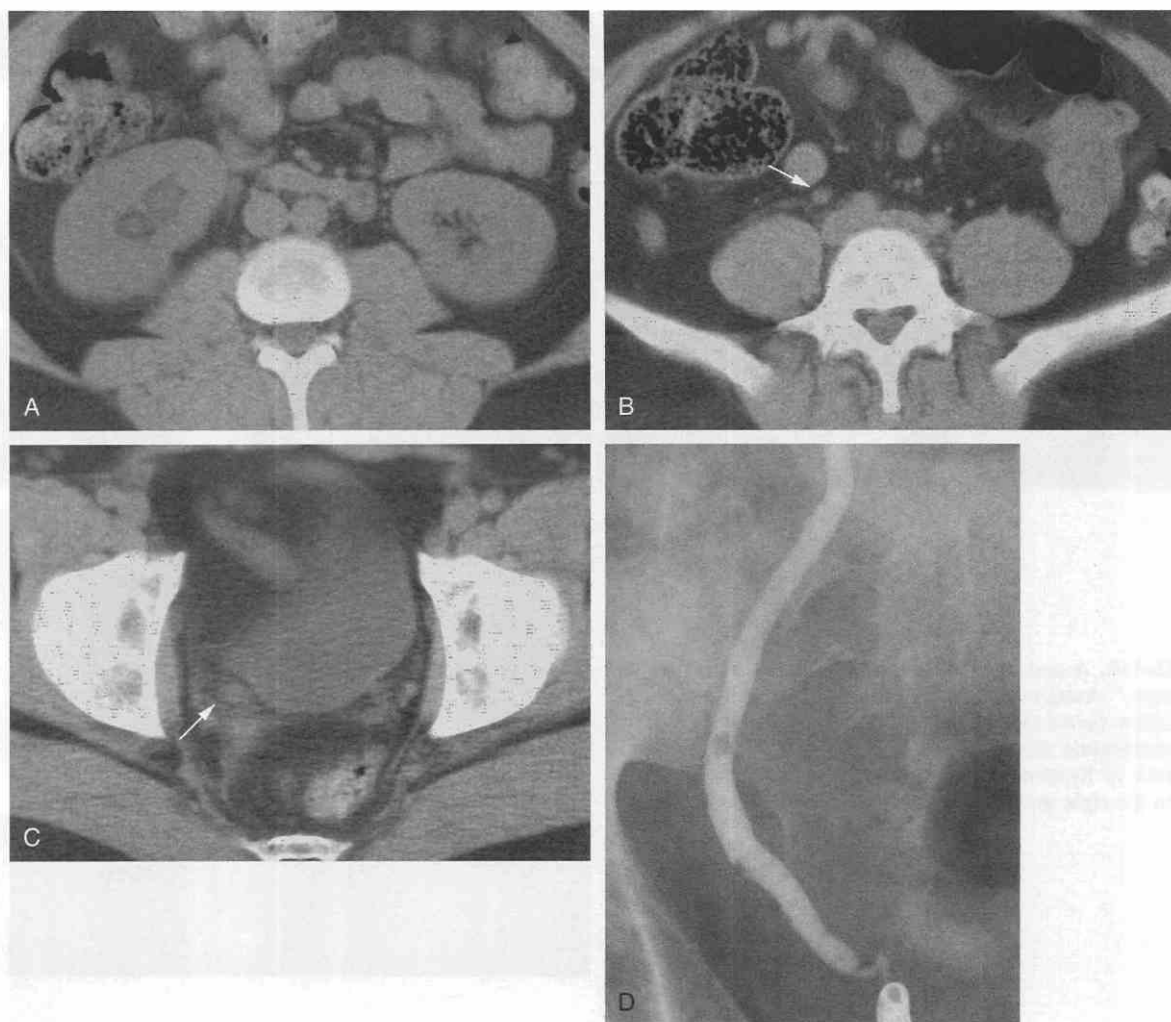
Protease inhibitor deposition in a 35-year-old man with human immunodeficiency virus disease who is undergoing indinavir therapy. *A*, Axial non-contrast CT scan reveals hydronephrosis and minimal perinephric stranding of the right kidney. *B*, A more caudal scan shows hydroureter (*arrow*). *C*, More caudal scan demonstrates the persistence of hydroureter to the level of the ureterovesicular junction (*arrow*). No calcification was identified. *D*, Retrograde ureterogram shows multiple filling defects in the distal right ureter. Stricture of the ureter distal to the indinavir fragments is likely caused by recent stone impaction near the ureterovesicular junction. (From Dalrymple NC, Casford B, Raiken DP, et al: Pearls and pitfalls in the diagnosis of ureterolithiasis with unenhanced helical CT. *Radiographics* 20:439-447, 2000.)
